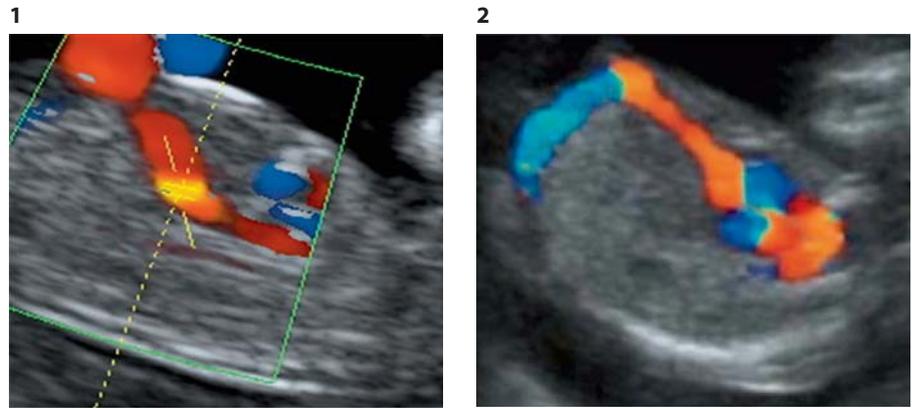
Ultrasound picture of a 12-week fetus demonstrating a normal DV with the typical yellowish aliasing above the umbilical sinus.
